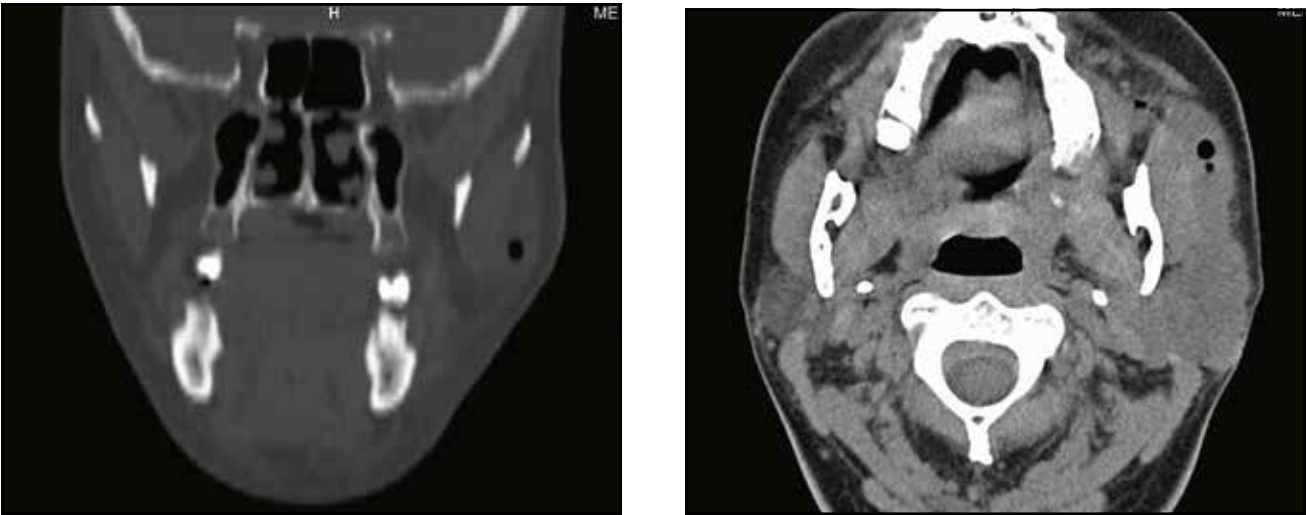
Cranio-facial CT scan (coronal slice – left, axial slice – right) findings described as a mass tumor at the level of the left parotid gland, with important infiltration into the adjacent structures. As one can see, on the CT scan there are air bubbles in the mass tumor, aspect which can suggest an abscess; this observation was confirmed during the surgery.
